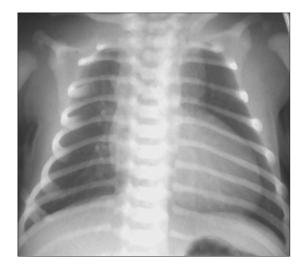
Baby Smith's chest radiograph.
